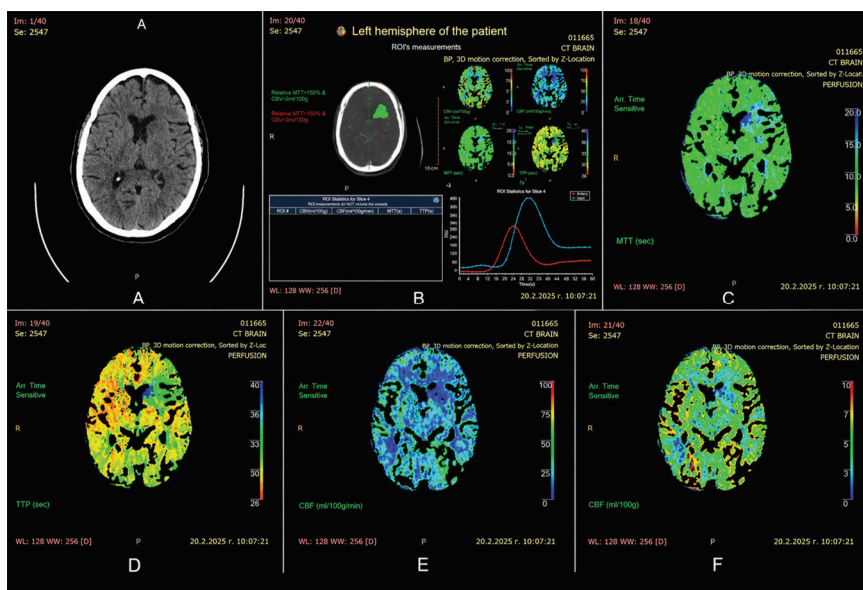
Non-contrast CT (A) and perfusion maps (B-F) demonstrating ischemic changes in the left basal ganglia. Perfusion maps show prolonged MTT and TTP with reduced CBF and relatively preserved CBV, consistent with ischemic penumbra
